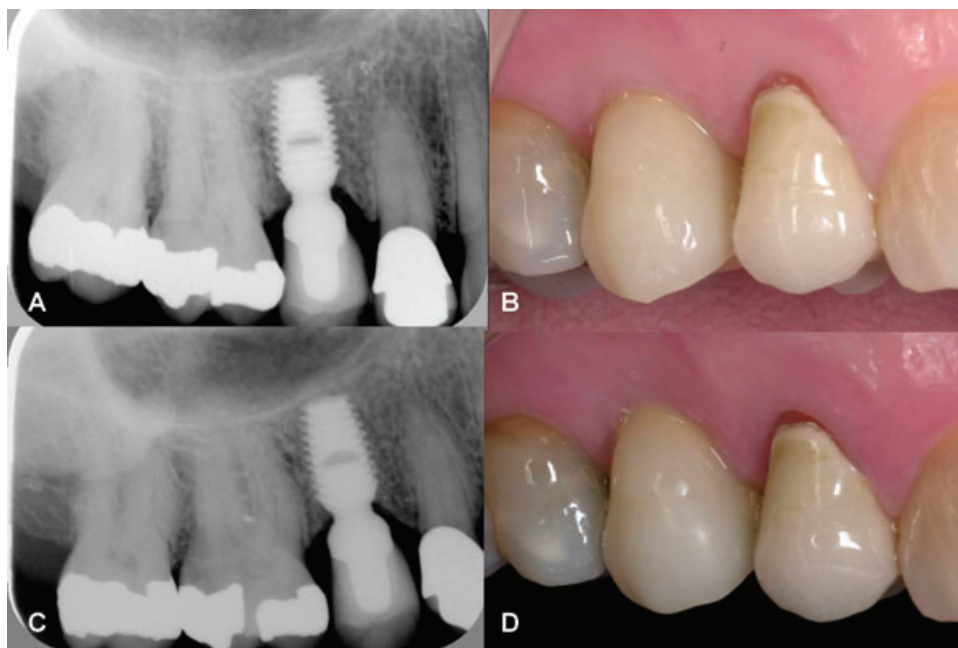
Clinical and radiographic view of an IAC on a maxillary right second premolar, at crown insertion (A, B), and at the recall appointment 27 months later (C, D).
